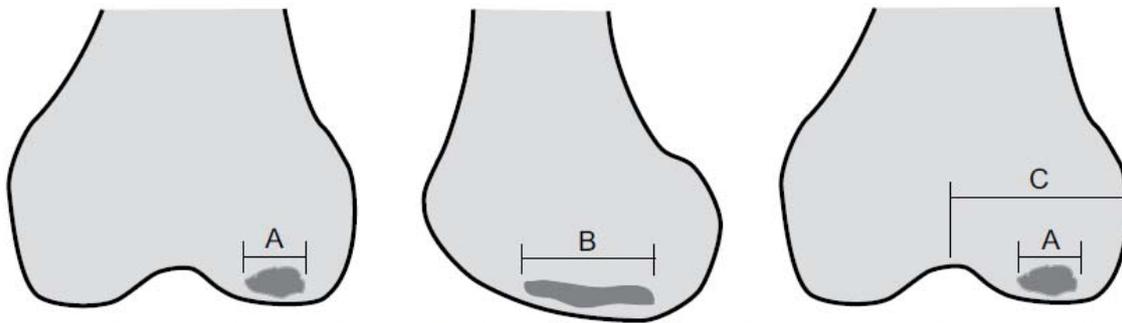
Lesion size can be estimated by measuring the greatest width of the lucency on an AP radiograph (A) and multiplying it by the greatest length of the lucency on a lateral radiograph (B), in addition to the ratio of lesion width to total width of the affected condyle (A divided by C). (Data from Aglietti P, Insall JN, Buzzi R, et al. Idiopathic osteonecrosis of the knee. Aetiology, prognosis and treatment. *J Bone Joint Surg Br* 1983;65:589.)
